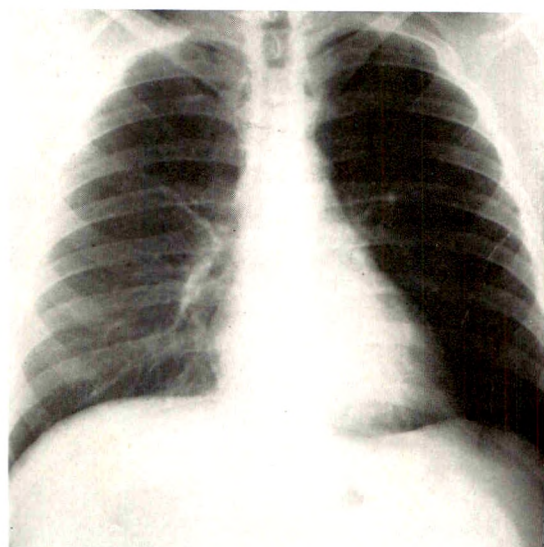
Case III. February 16, 1962: Progress roentgenogram 2 weeks following second admission.
